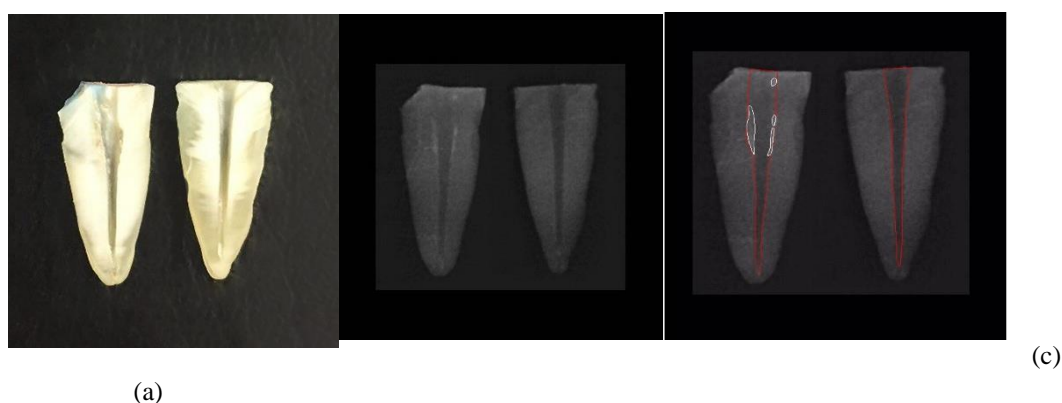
Longitudinal section of halves filled with AH-26 sealer after retreatment; a: photograph, b: digital periapical radiograph, c: AutoCAD analysis
